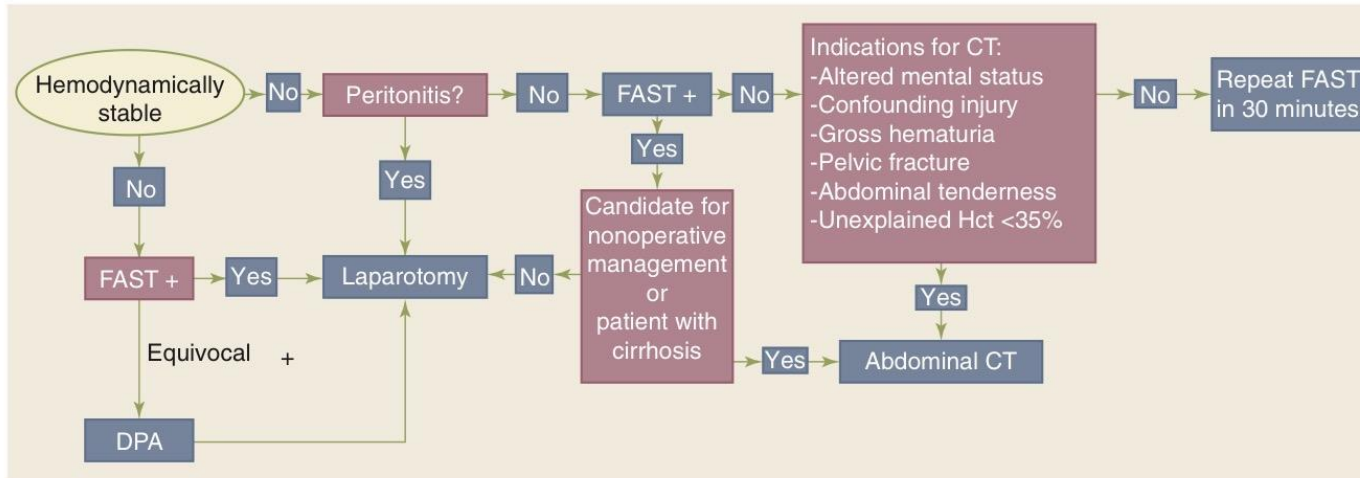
Algorithm for the initial evaluation of a patient with suspected blunt abdominal trauma. CT = computed tomography; DPA = diagnostic peritoneal aspiration; FAST = focused abdominal sonography for trauma; Hct = hematocrit.
